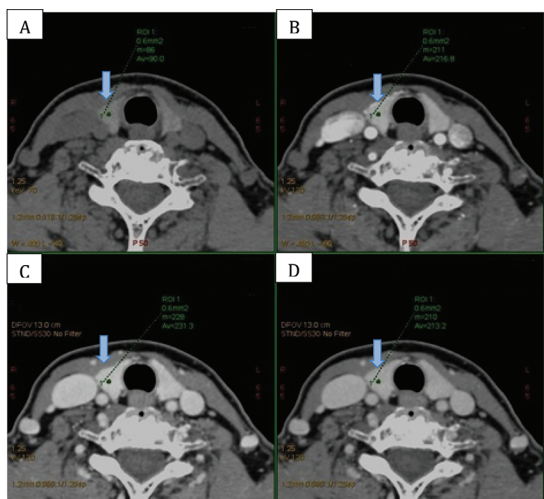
4D-CT: (A) noncontrast; (B) post-contrast 30-second delay; (C) post-contrast 60-second delay; and (D) post-contrast 90-second delay of the same patient profiled in Figure 3 shows arterial enhancement and contrast washout of thyroid gland, and high attenuation during the pre-contrast phase as 90 HU.
